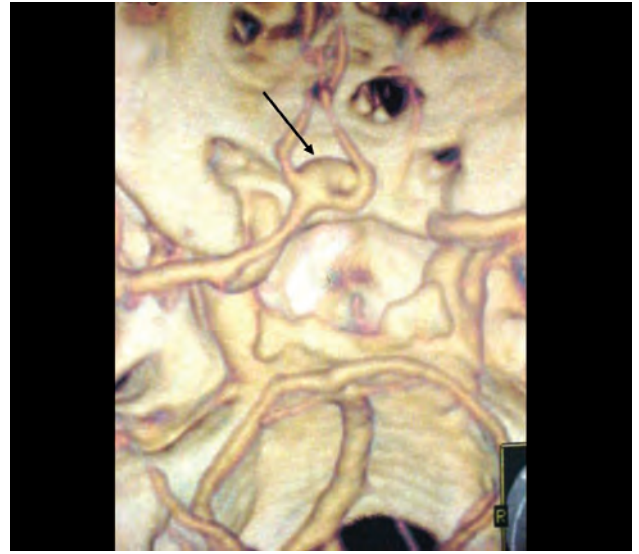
3D reconstruction of the CT angiogram showing ACoAA
